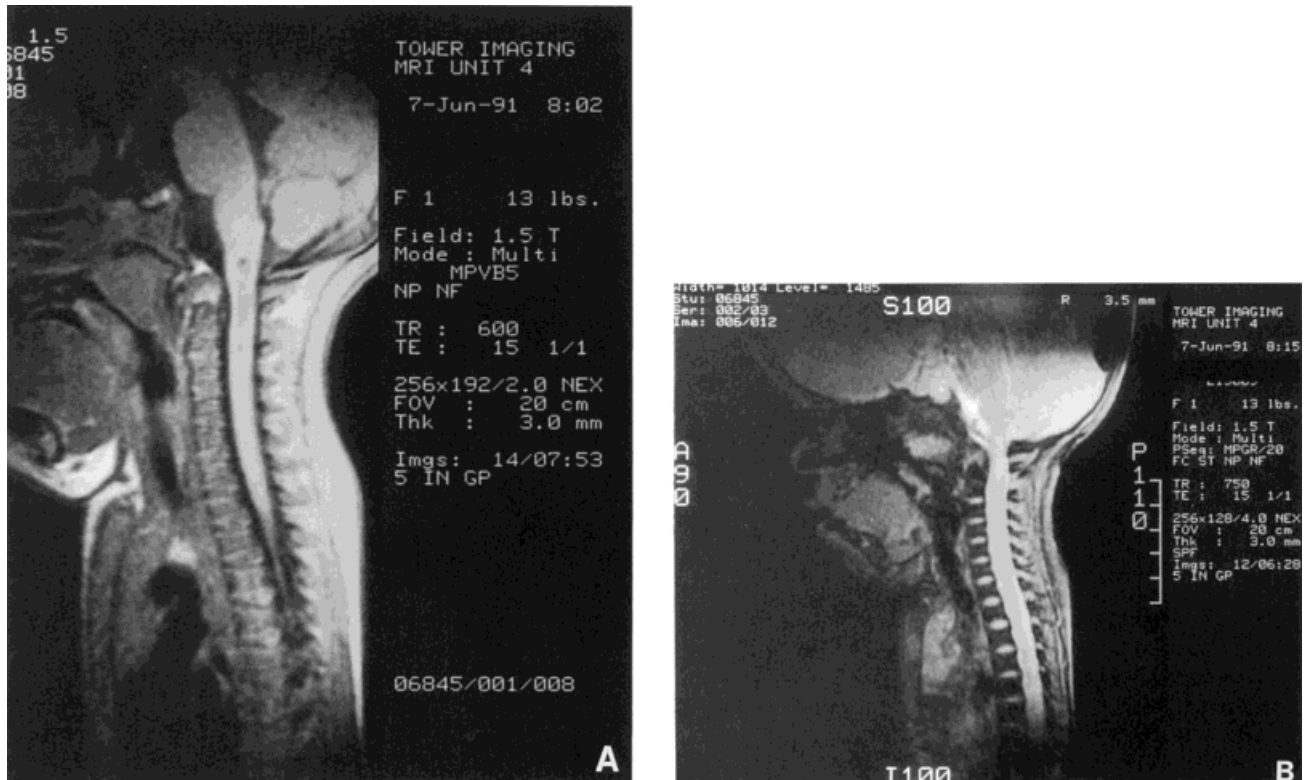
Four-month-old infant with achondroplasia. A, B: MRI of the cervical cord and brainstem (pre-operatively) with a syrinx of the cervical cord and cervical cord compression at the medullary-cord junction.
